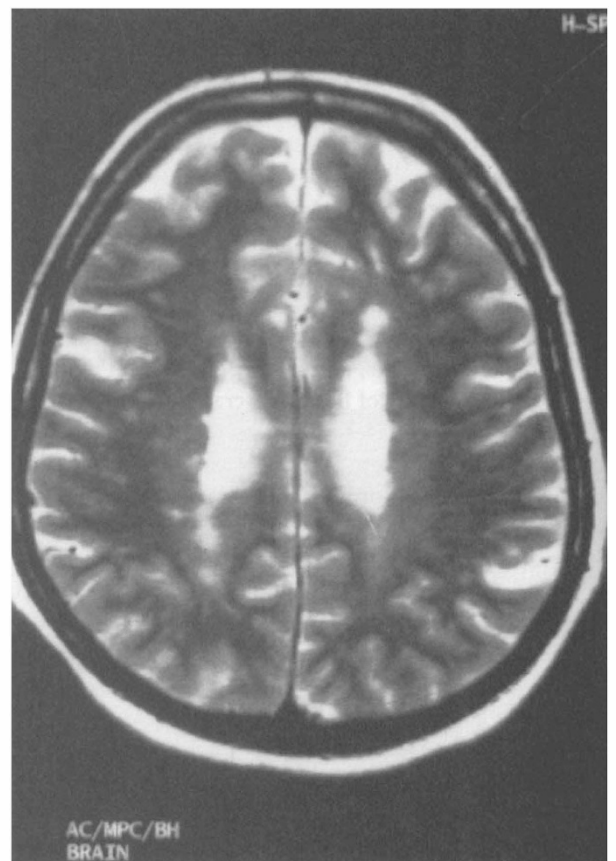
Axial T2-weighted MR sequence shows multiple small foci of high signal intensity involving the periventricular region.
